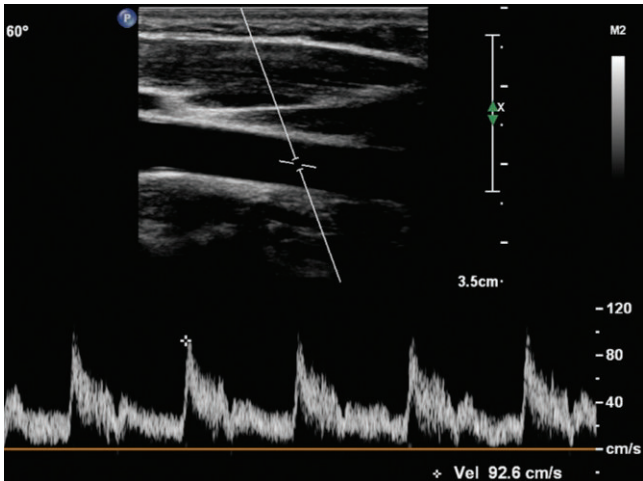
Spectral Doppler angle correction is correct and set at 60 degrees, which is acceptable. Note the little difference between 60 degrees and 50 degrees, 92 versus 90 cm/s.
